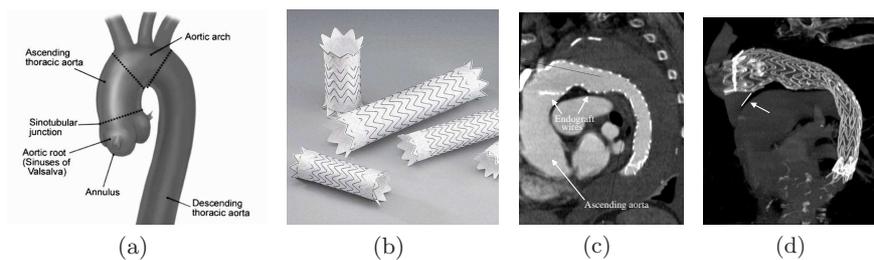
Anatomy of the thoracic aorta (a), examples of endovascular grafts (b), as well as a 2D section (c) and a maximum intensity projection (d) of a 3D CTA of a patient after implantation of an EVG into the aortic arch. The EVG shows a significant misalignment w.r.t. the inner contour of the proximal aortic arch (see the arrow, (d)).
